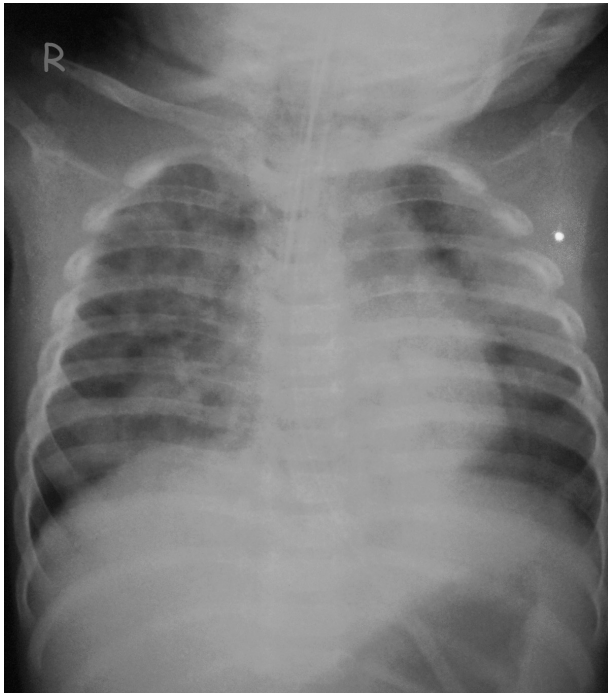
Chest radiograph (frontal view) of the 6-month-old infant showing multiple bilateral fluffy infiltrates in the lung fields, with normal cardiac silhouette consistent with acute respiratory distress syndrome.
